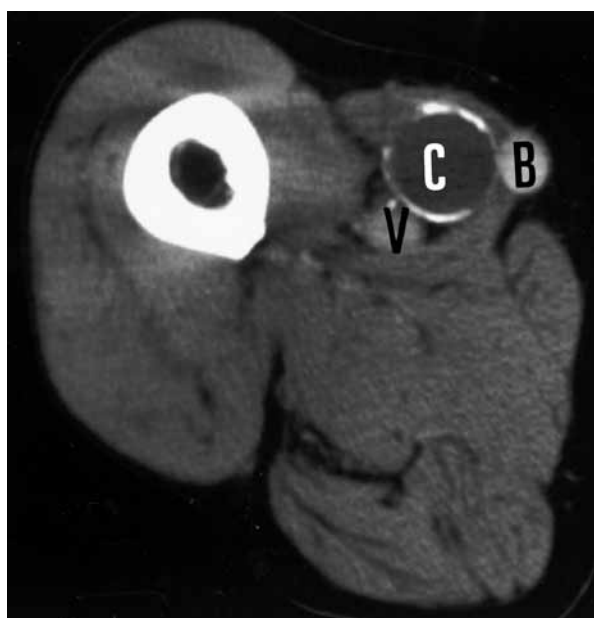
CT scan demonstrating the superficial venous bypass (B), the adjacent large cyst (C) and the femoral vein (V). No contrast is seen in the cyst.
